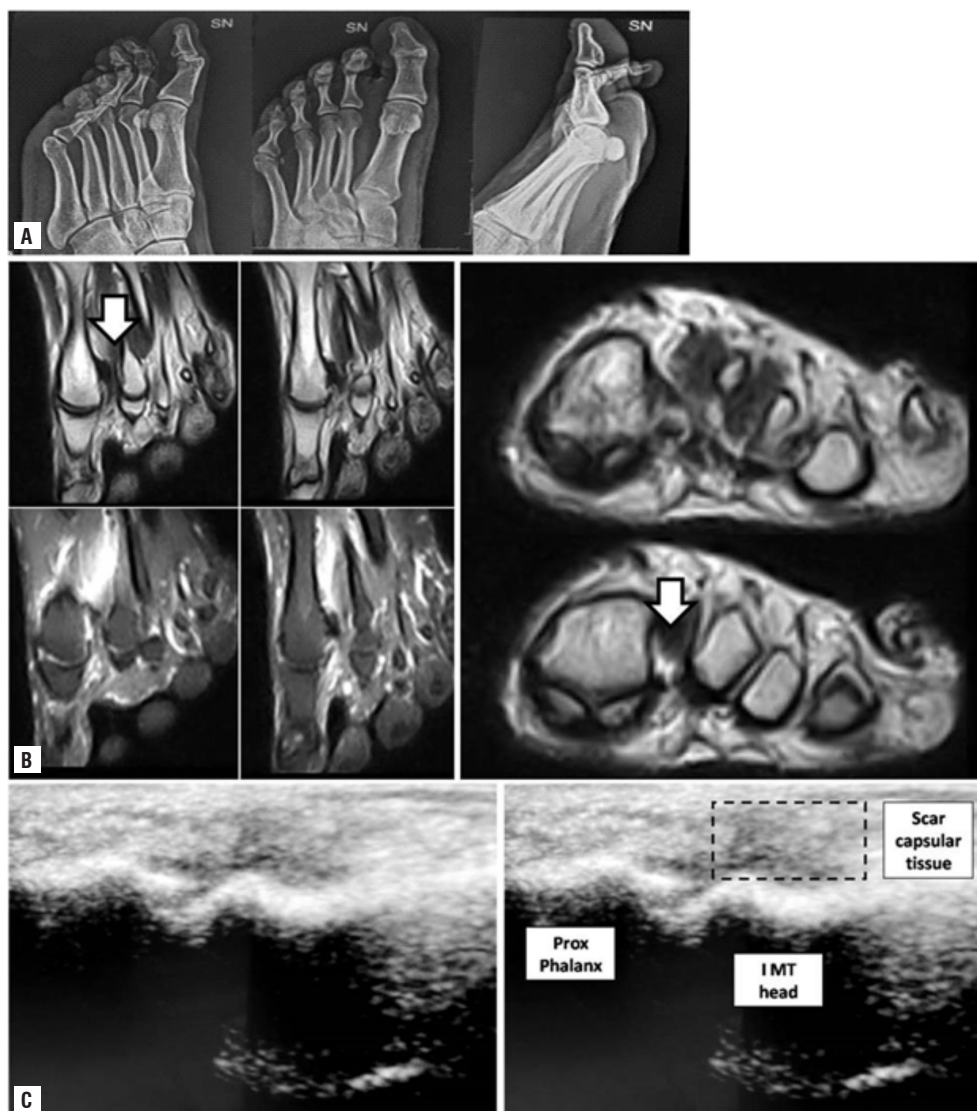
Pre-operative lesion. A) Traditional X-ray showed correct alignment of the first MTPJ with the *hallux abductus* angle 3°; B) magnetic resonance imaging of the abductor tendon detachment; C) ultrasonography of the lateral capsular ligamentous structures rupture (Policlinico Bari, August 2020)
